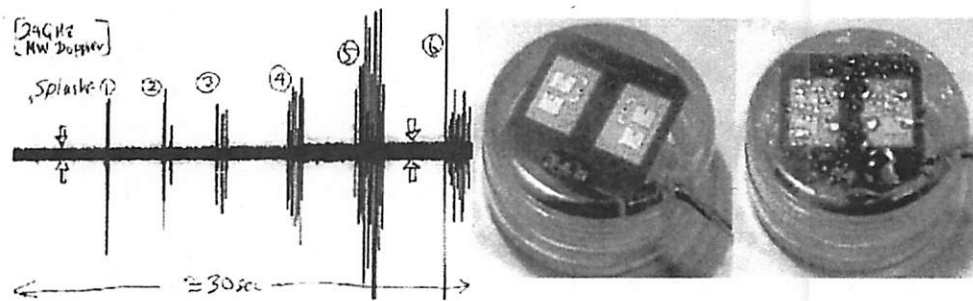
24GHz microwave Doppler unit can be mounted inside plastic (acrylic, in this case, left) container with almost no degradation of sensitivity, can also retains sensitivity even with sprayed water drops sticking to its surface (right).
